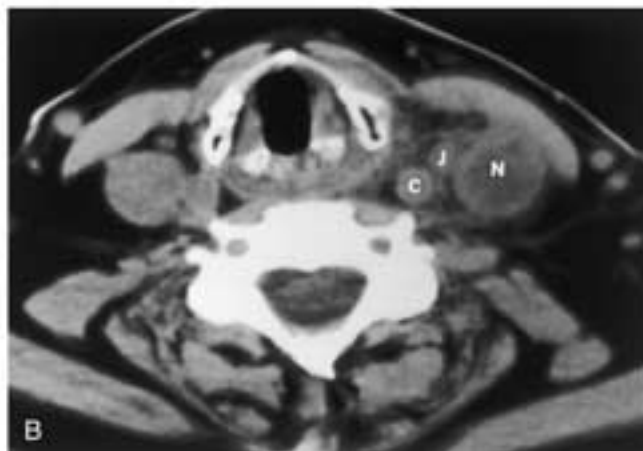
Anaplastic thyroid carcinoma. A, Unenhanced axial CT scan shows an infiltrative mass in the left lobe of the thyroid gland. Extension outside the thyroid capsule is suggested by soft-tissue stranding in the adjacent neck fat (arrow). There is also obliteration of the fat plane between the thyroid and the esophagus (long arrow, esophageal lumen). B, Inferior image shows a necrotic metastatic lymph node (N). C, Carotid; J, jugular vein.
